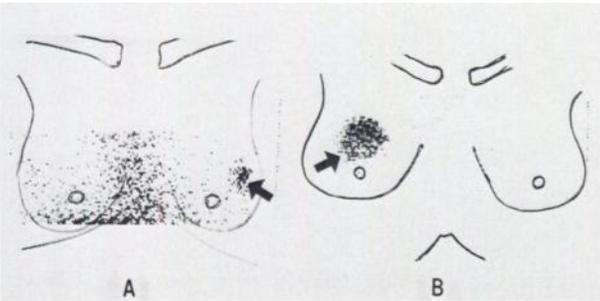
Cases 7 and 8. Breast carcinoma. Gallium-67 scintigrams (A and B) are strongly positive (indicated by arrow). As seen in second scintigram (B) uptake by liver and vertebrae is slight when compared with uptake of ^{67}Ga -citrate by tumor. In Case 7 (A) patient was operated 5 days after administration of ^{67}Ga -citrate. Radioactivity in cancer tissue was 9.4 times higher than that in surrounding unaffected breast tissue.
